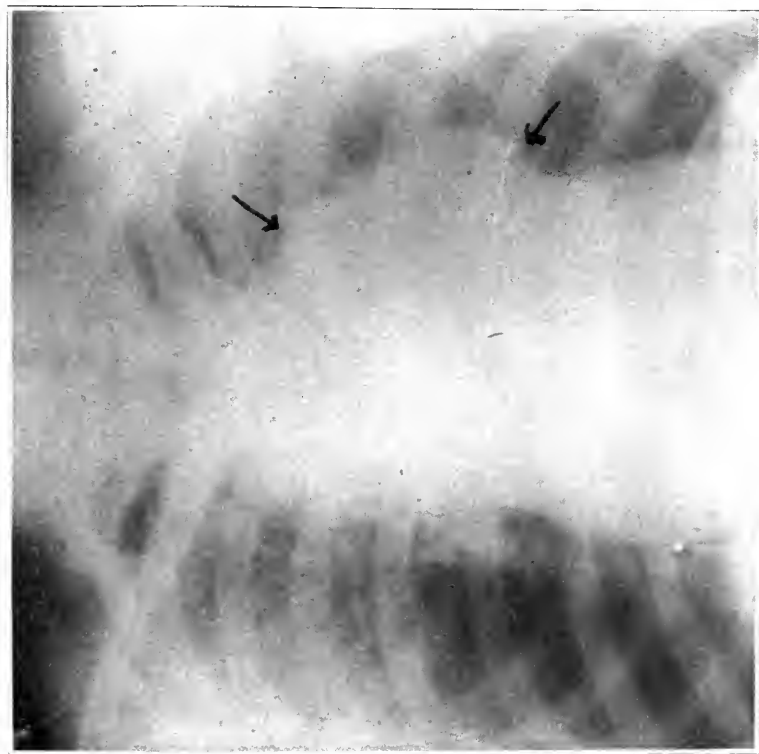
Roentgenogram of patient suffering from syphilitic aneurysm involving descending portion of arch of aorta. This is an unusual location for the syphilitic type due to syphilis.
